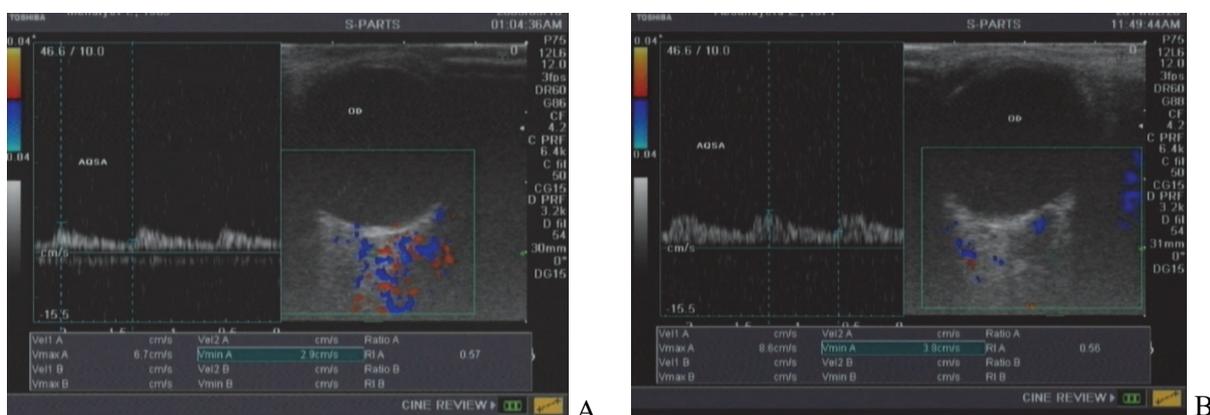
Doppler ultrasonography of SPCA. A – before treatment. B – after treatment.
